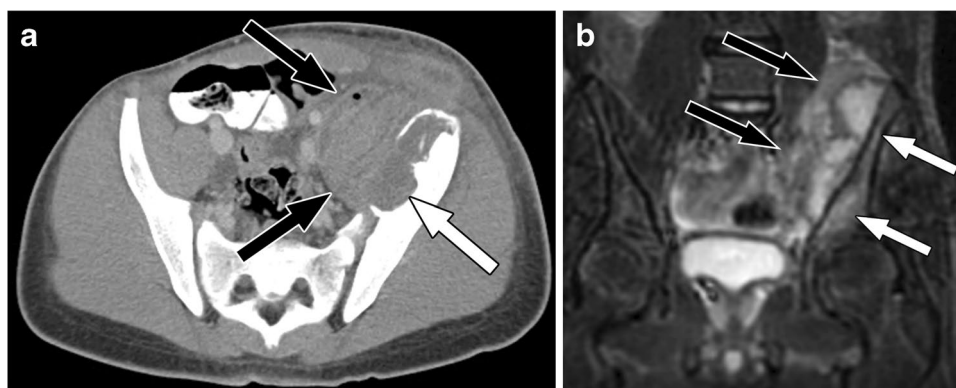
13-year-old boy with osteomyelitis due to disseminated coccidioidomycosis. a Axial pelvic CT image with IV and oral contrast materials shows destruction of the left ilium (white arrow) with a contiguous large area of mixed phlegmon and abscess containing a small focus of gas extending centrally into the pelvis (black arrows) and superficially into the overlying soft tissues. The left iliac vessels
